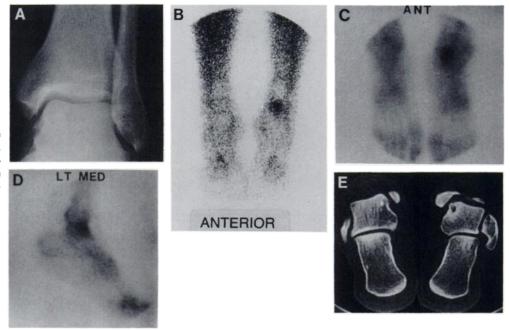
(A) Normal plain radiograph of the left ankle in a patient with persistent posttraumatic left ankle pain. (B–D) Blood-pool and delayed bone scan images of the feet taken from anterior and medial aspect of the left ankle demonstrates markedly increased activity in the talus. This pattern is compatible with OCTDF. (E) Coronal CT confirmed the presence of osteochondral cyst in the medial aspect of the left talus (Stage IIA).
